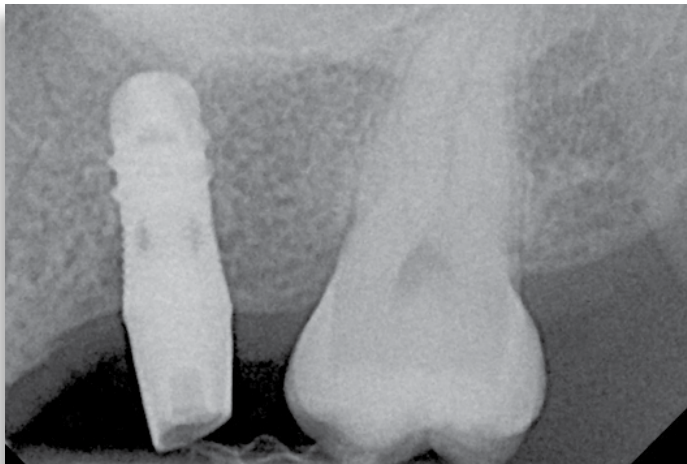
A radiograph is taken to ensure complete seating.
